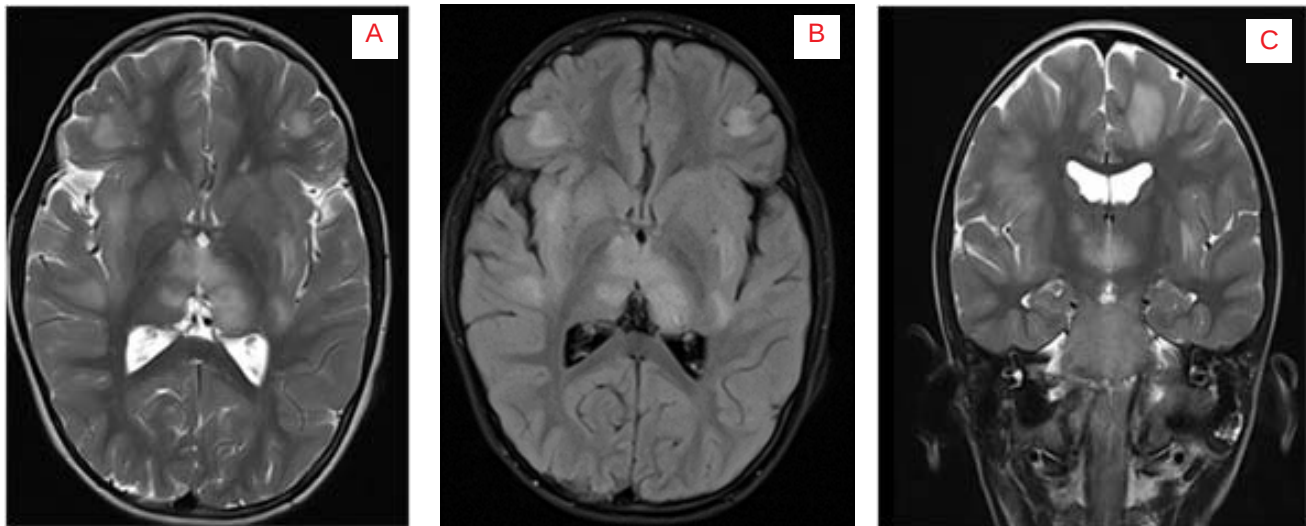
MRI images of a 6-year-old boy who presented with ADEM.
